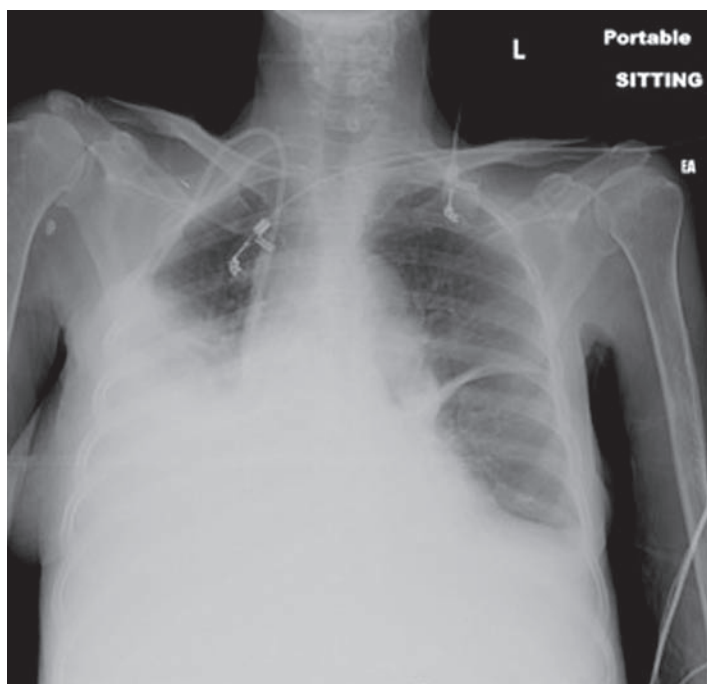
Portable upright chest radiograph reveals bilateral pleural effusion.
